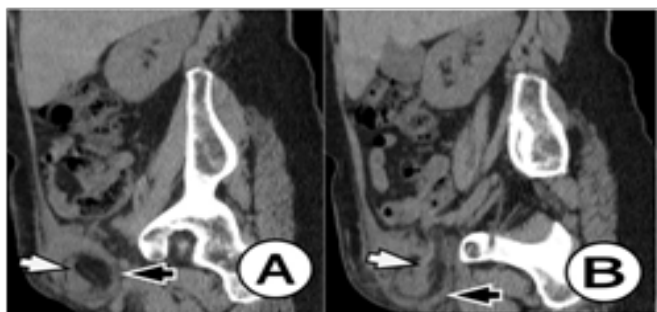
A 69-year-old female with right-sided Amyand's hernia. Sagittal reformatted CT image of the abdomen: Sagittal reformatted CT image shows an inflamed appendix (white arrow) extends into the small right inguinal hernia (black arrow). There were no signs of obstruction or strangulation.
